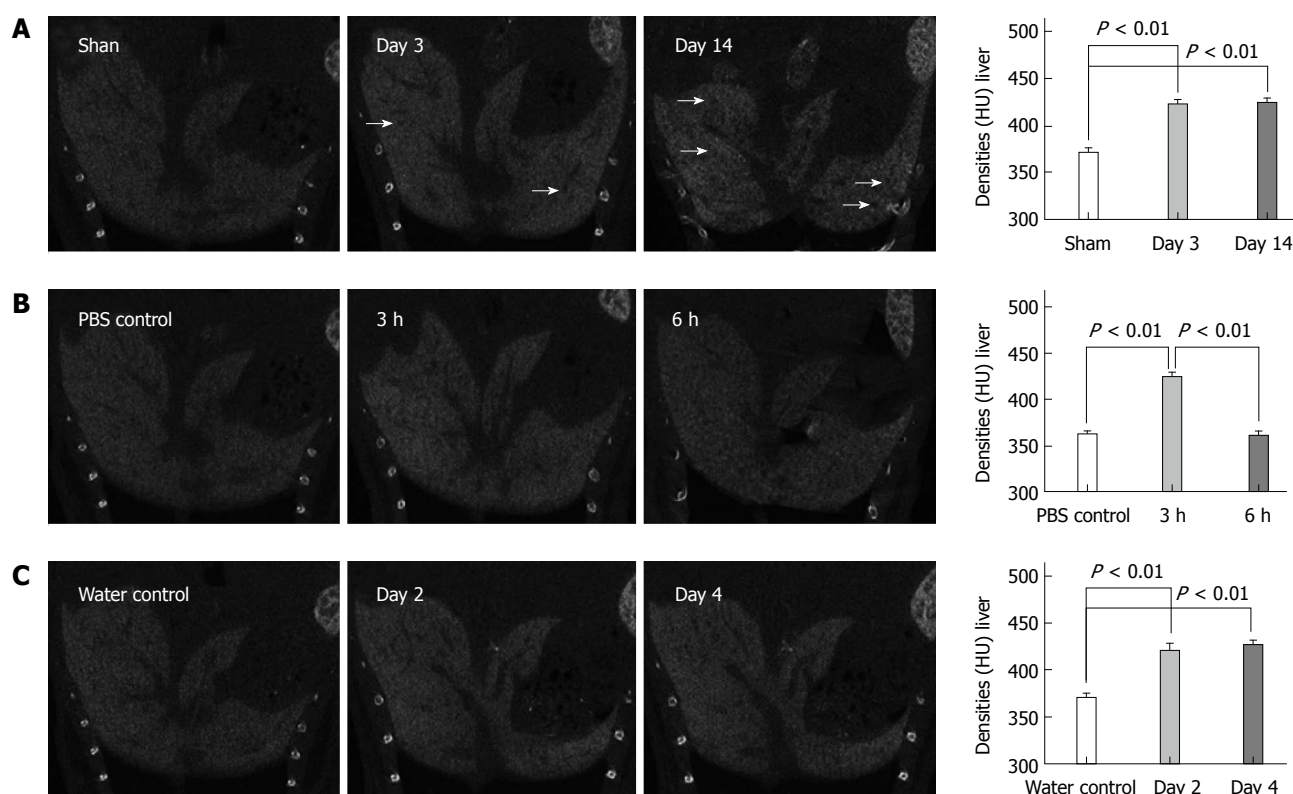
Contrast-enhanced computed tomography images of liver lesions induced by bile duct ligation (A), lipopolysaccharide/D-GalN (B) and alcohol (C); density measured in the livers are reported as HU. The black arrows indicate black regions with low densities. Values are represented as the means of triplicate values and presented as the mean  $\pm$  SD.
